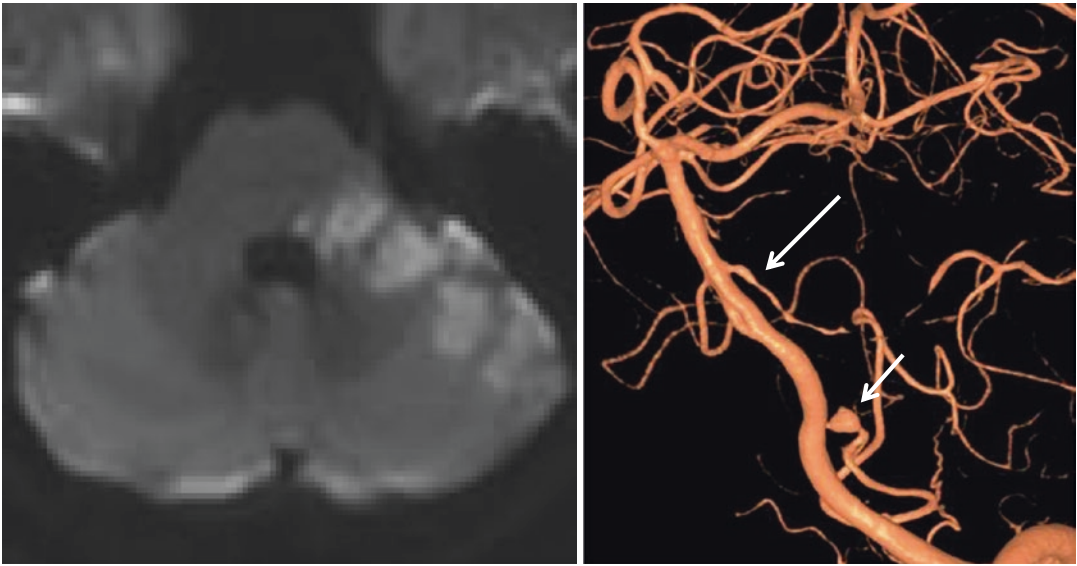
A 63-year-old man developed dizziness and gait instability. Examination showed left facial palsy, hearing difficulty, dysarthria, and left limb ataxia. Diffusion-weighted MRI showed an infarction in the left anterior inferior cerebellar artery (AICA) territory (left
